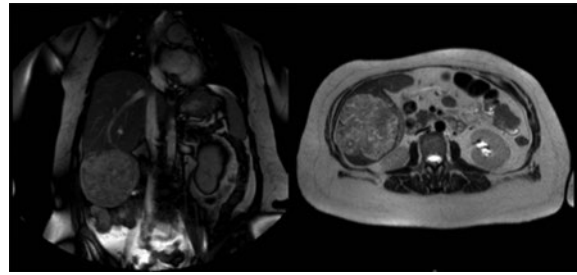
Lesion on magnetic resonance imaging.
